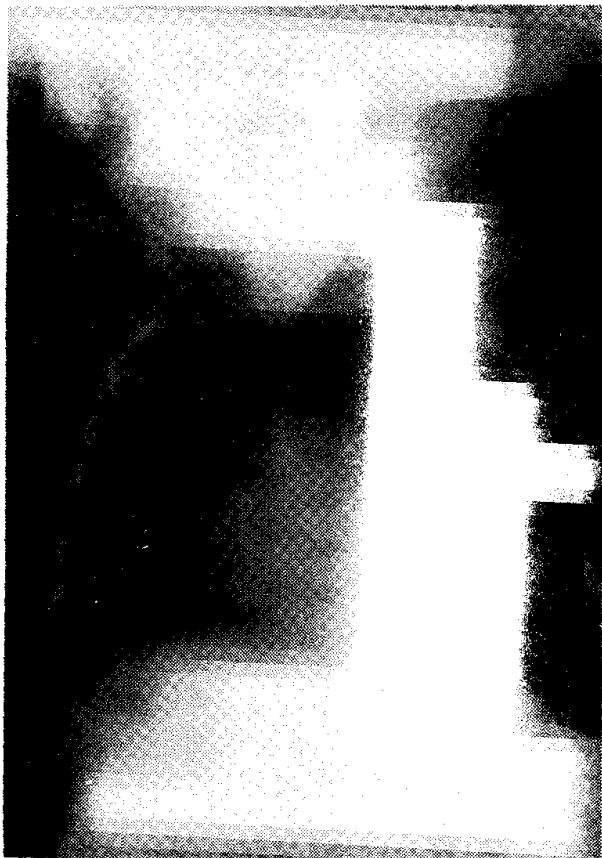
X-ray chest PA showing the foreign body.
